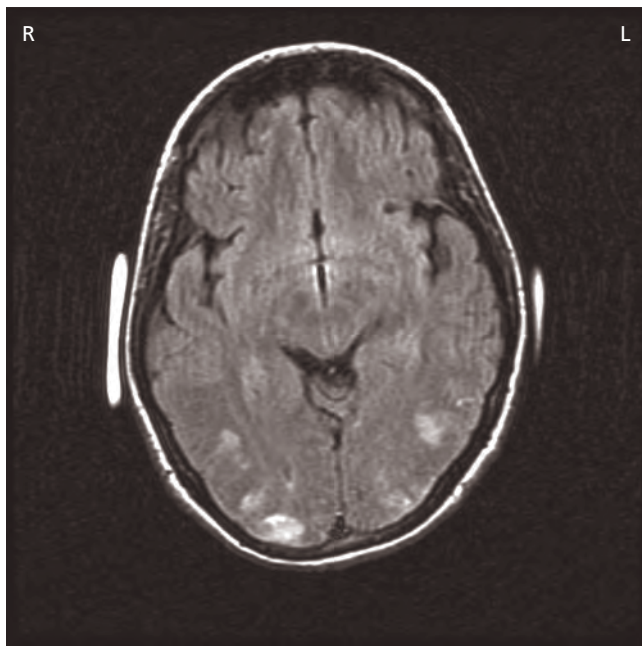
Case of PRES: axial FLAIR MRI of a 17-year-old woman who presented with seizures and complete visual loss in the context of uncontrolled hypertension 1 week after delivery. Note patchy high signal abnormalities bilaterally in the parieto-occipital regions. One month later these imaging abnormalities had fully resolved.
